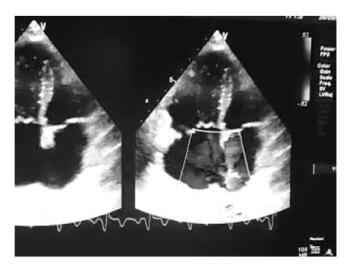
Echocardiography (apical 4 chamber view) showing large OS ASD (29 mm) with bidirectionalshuntwithdilated RA& RV.
